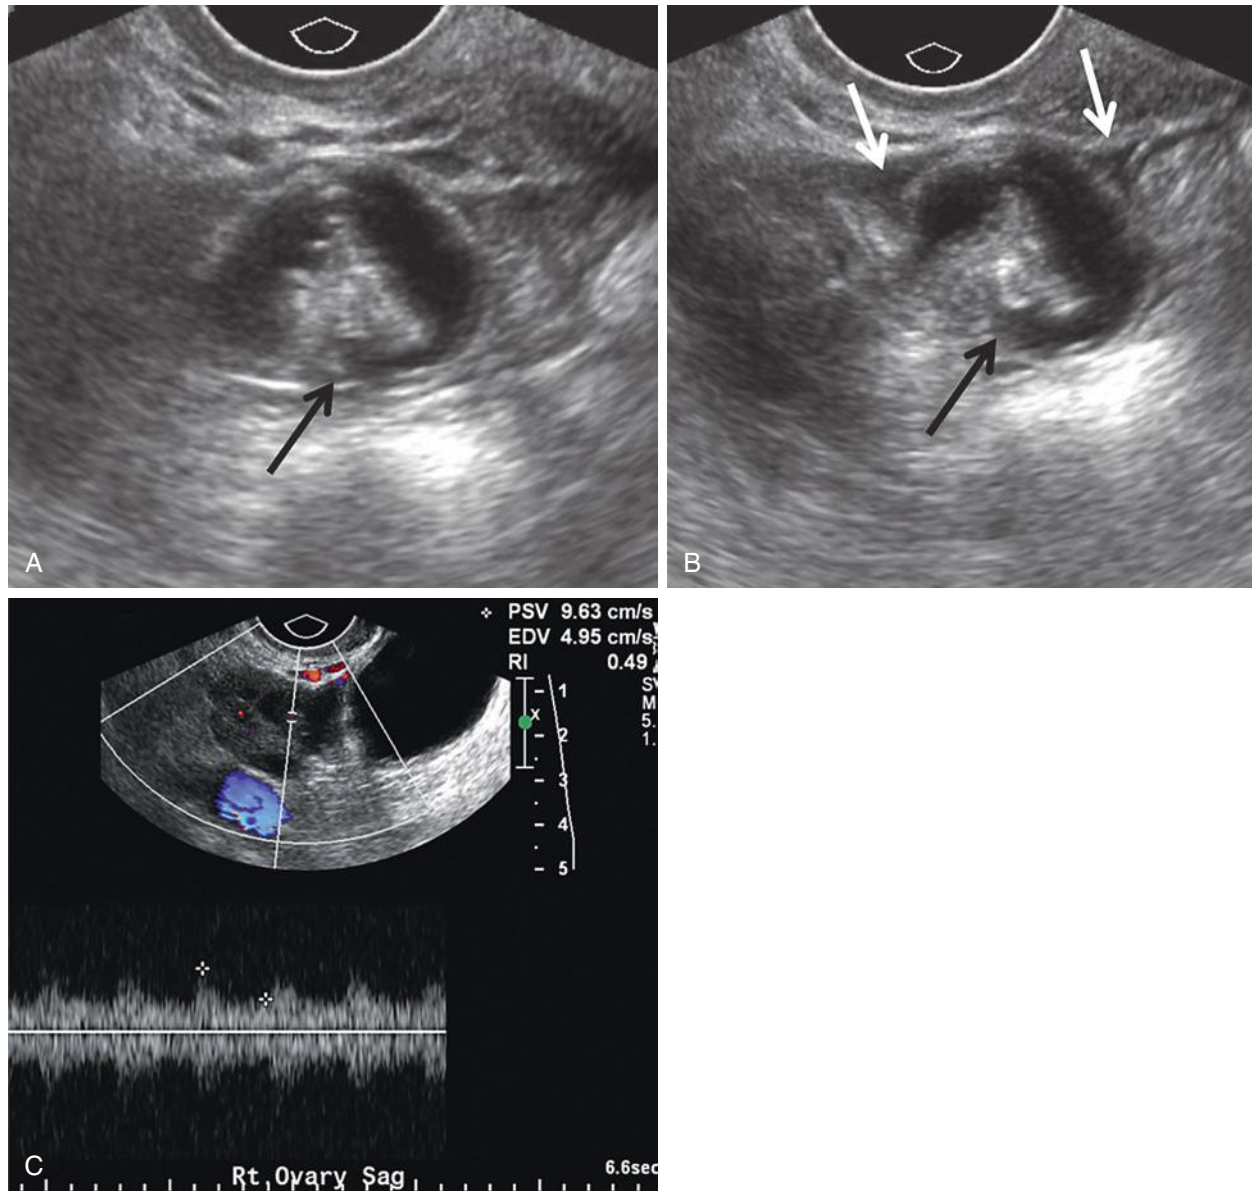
Isolated torsion of the fallopian tube. A 15-year-old girl with acute onset, severe right lower quadrant to midline pelvic pain. A and B, Note dilated tubular fluid-filled structure in an upside-down U-shaped configuration with a pointed or “beaked” appearance at the medial end (*black arrow*), as a result of twisting or torquing. The twisted fallopian tube was in an abnormal location, situated above the uterus toward the midline. There is a small volume of adjacent free fluid (*white arrows*). C, The right ovary appears normal in size and morphologic appearance with normal flow on color and spectral Doppler interrogation.
